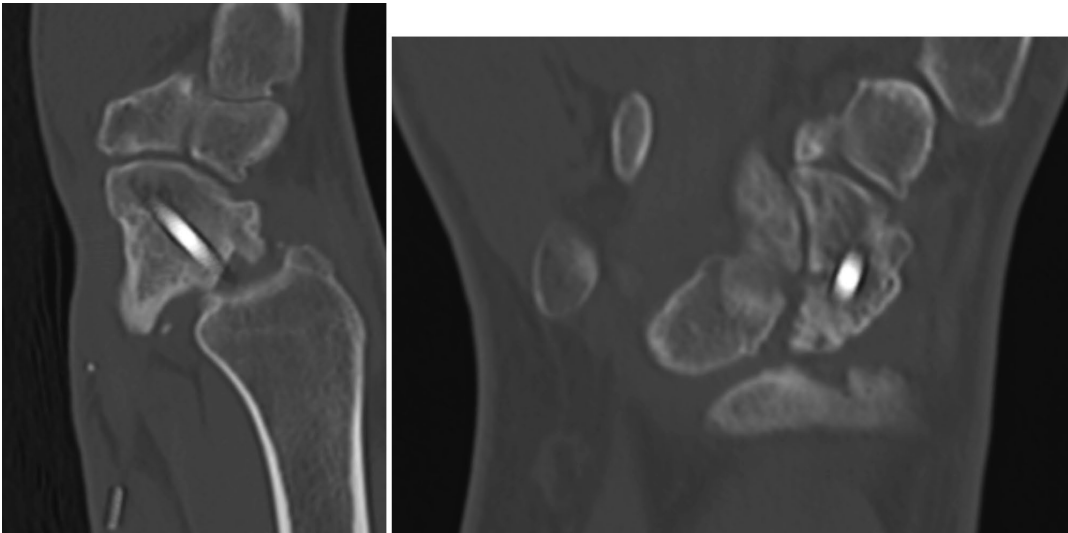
CT right wrist eight months status post medial femoral condyle vascularized bone flap to the right scaphoid.
